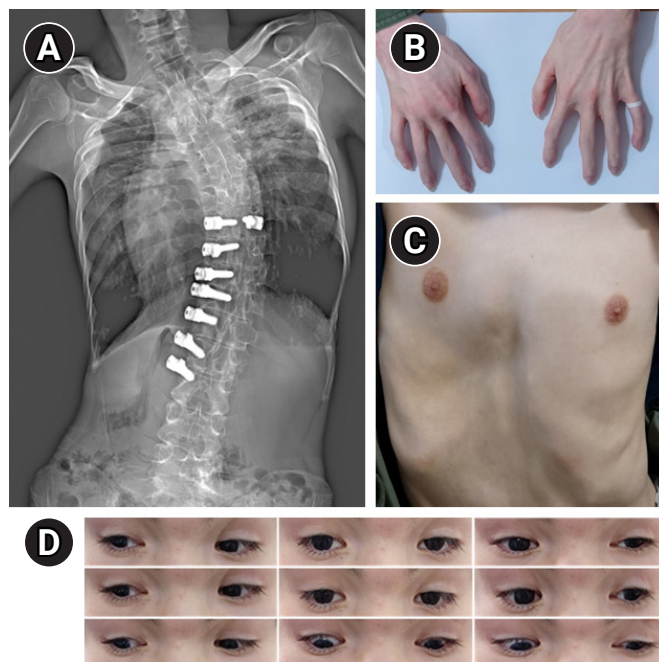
Clinical features of a patient with a novel *de novo* heterozygous variant in *PIEZO2*. (A) Whole-spine X-ray image. (B) Arachnodactyly. (C) Pectus excavatum. (D) The nine cardinal positions of the gaze.
